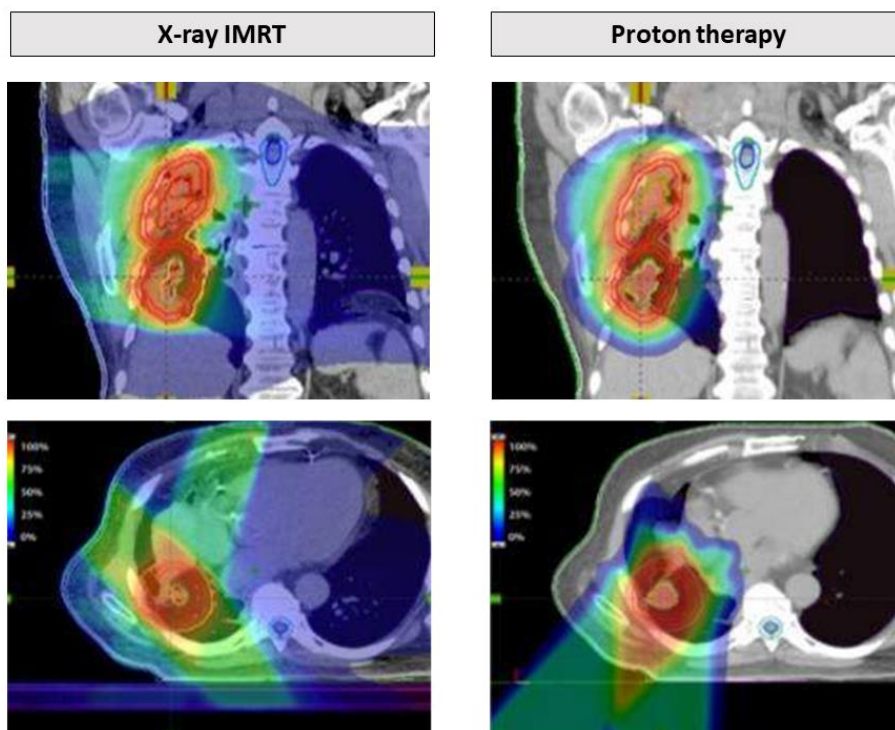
Example of treatment planning for the irradiation of non-small cell lung carcinoma. Compared to X-rays, protons enable a more precise tumor targeting while limiting irradiation of healthy tissues (the opposite lung and spinal cord). Adapted from [59].
